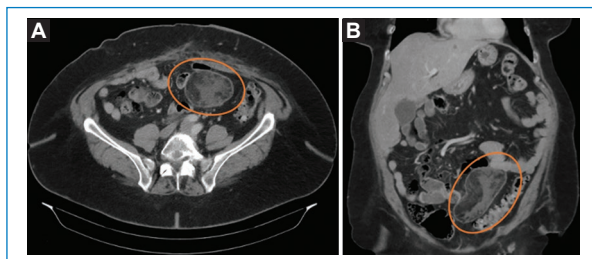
A 57-year-old female with history of type 2 diabetes, obesity, pulmonary embolism and squamous cell carcinoma originating in an ovarian teratoma, treated by total hysterectomy with bilateral salpingo-oophorectomy, omentectomy and pelvic and para-aortic lymphadenectomy. She presented to the emergency department for abdominal pain secondary to an incarcerated ventral hernia. She underwent urgent surgery with hernioplasty and dermolipectomy. A and B: postoperative computed tomography, performed because of persistent abdominal discomfort, revealed a well-encapsulated fatty lesion of approximately 12 × 8 cm in the anterior abdominal cavity, with inflammatory changes suggestive of omental infarction (circles).
